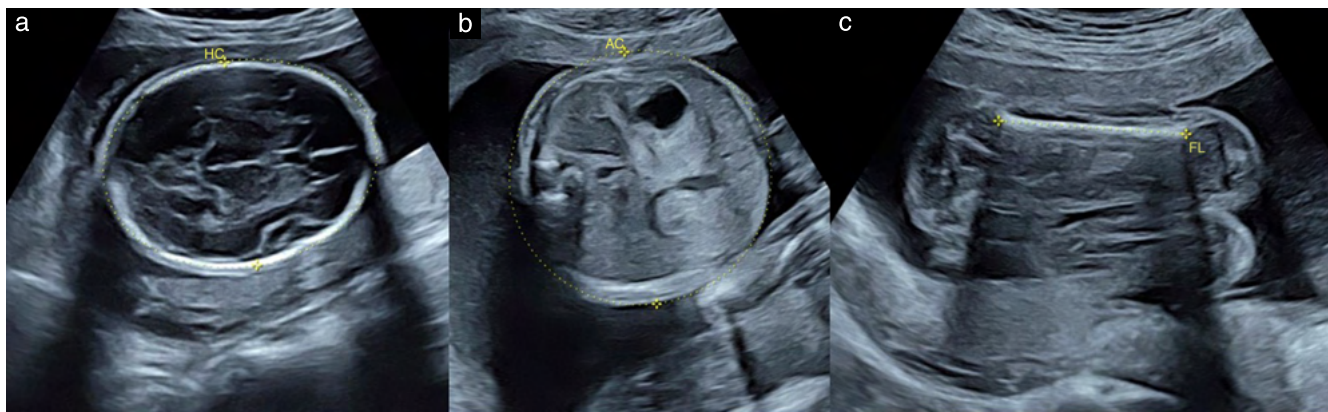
Standard fetal biometry. Sonographic measurements of: (a) head circumference (HC), (b) abdominal circumference (AC) and (c) femur length (FL).
